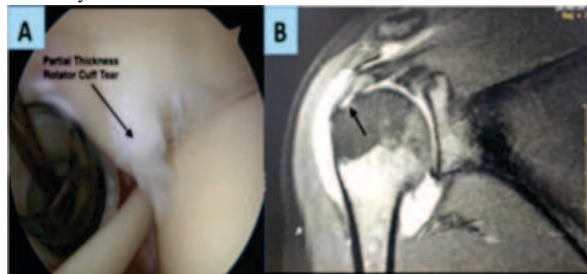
A: Arthroscopic image of articular side partial tear with fraying of tendon fibers from the humeral head. B: Coronal T1-weighted fat saturated MRI image showing tendinosis with rim-vent articular surface partial (A2) tear of supraspinatus tendon, along with mild joint effusion and fluid in the subacromial-subdeltoid bursa.
